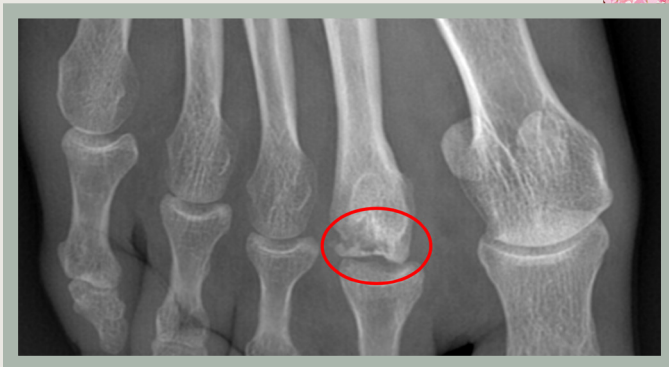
Radiographic appearance of Freiberg's disease. Direct radiography showed irregularity and flattening of the joint surface at the second metatarsal head (red circle), with the radiographic findings consistent with Smillie stage III Freiberg's disease
